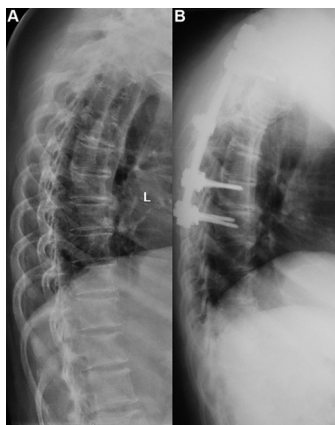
Ossification of ligamentum flavum T4–5 plus ossification of the posterior longitudinal ligament T4–6 with laminectomy T3–5 performed. (A) Preoperative and (B) postoperative radiographs of the thoracic spine.
